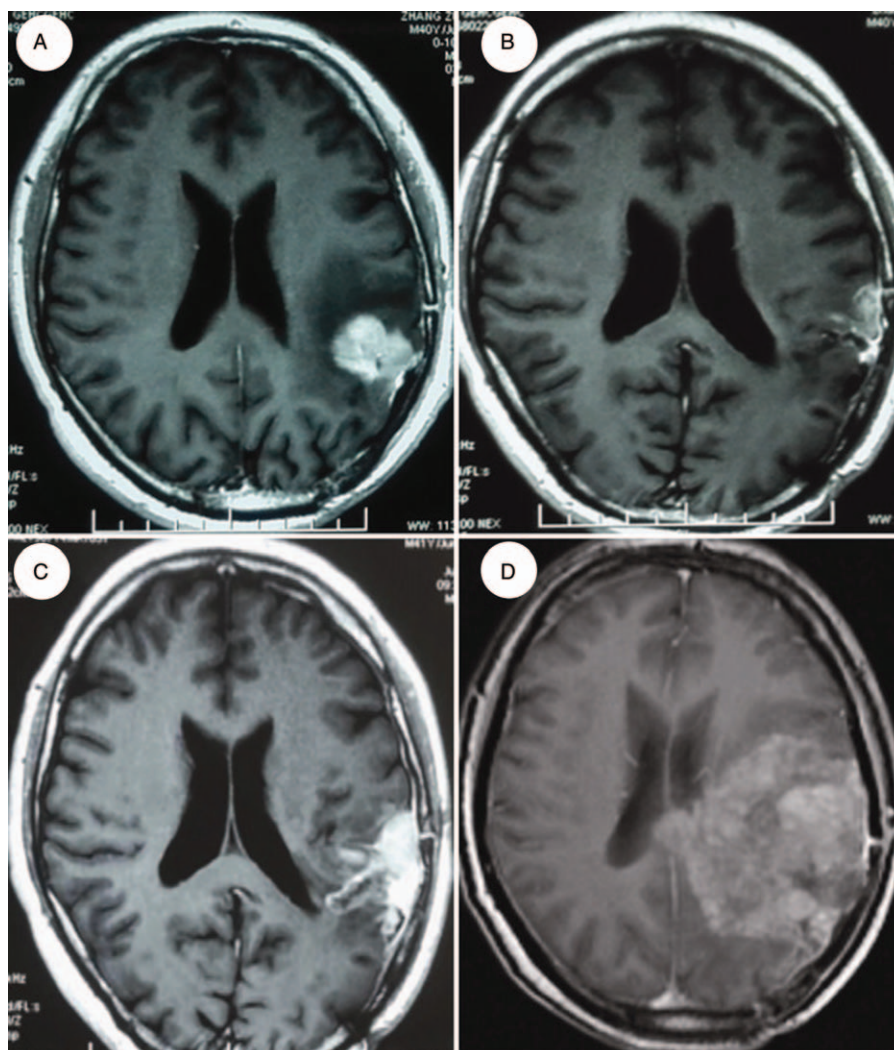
MRI of the patient (no. 1) with glioblastoma: (A) pretreatment MRI scan; (B) posttreatment MRI scan after 3 mo; (C) posttreatment MRI scan after 11 mo; (D) MRI scan of second relapse in April 2016. MRI=magnetic resonance imaging.
